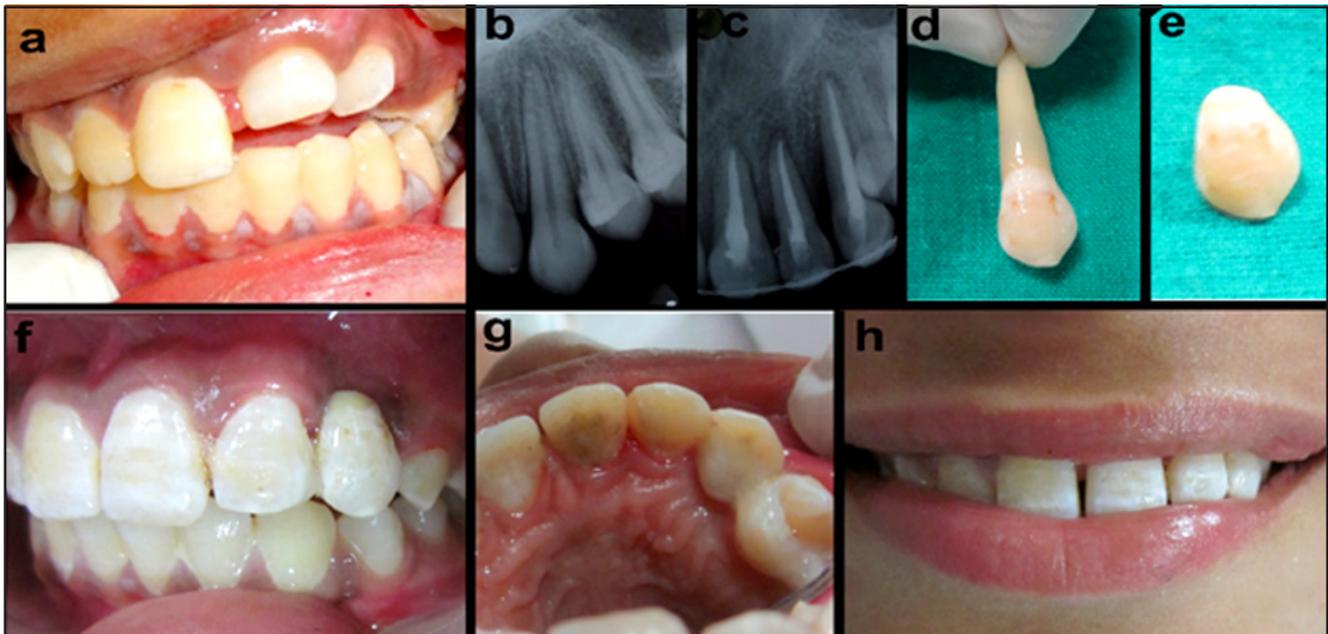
Case 2. (a) Preoperative clinical view showing intrusion of #21, #22 and avulsed #23. (b) IOPA radiograph taken to check the fit of avulsed tooth in the socket for reimplantation. (c) One month followup radiograph: severe periradicular bone loss. (d) Extracted tooth. (e) Crown ready to be used as natural tooth pontic. (f) Natural tooth pontic bonded using fiber reinforced splint. (g) Postoperative palatal view. (h) A pleasing smile is attained.
